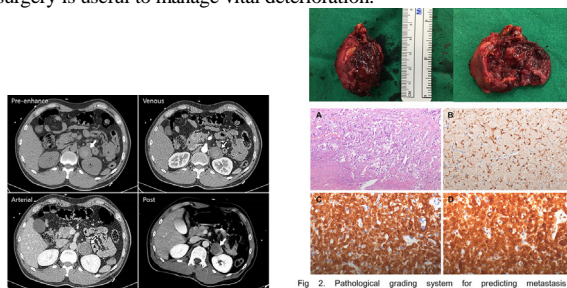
A-C, Low dose dynamic CT for evaluation of aorta and D, routine iodine-enhanced CT. A, Axial pre-contrast CT shows a 3.7cm mass with internal high density in the left adrenal gland. B, Arterial phase image shows no definite internal enhancement compared with pre-contrast image. C and D, Venous phase images with low dose protocol (C) and routine dose protocol (D). 9-10 min delayed image demonstrate peripherally confined enhancement with rarely enhanced central portion, suggests central necrosis.
